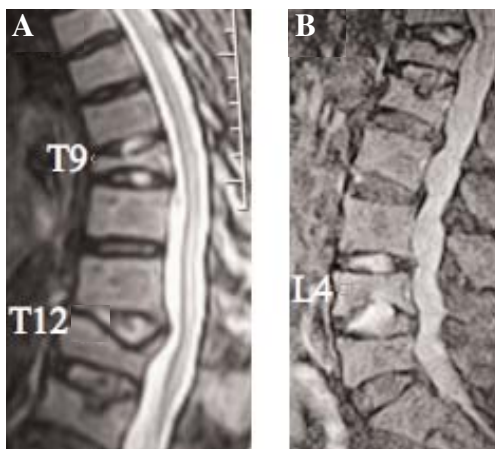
Preoperative T1-weighted MRI showing fresh fractures at T9, T12 and L4. A) Thoracic spine, with view of T9 and T12; B) Lumbar spine with view of L4.
